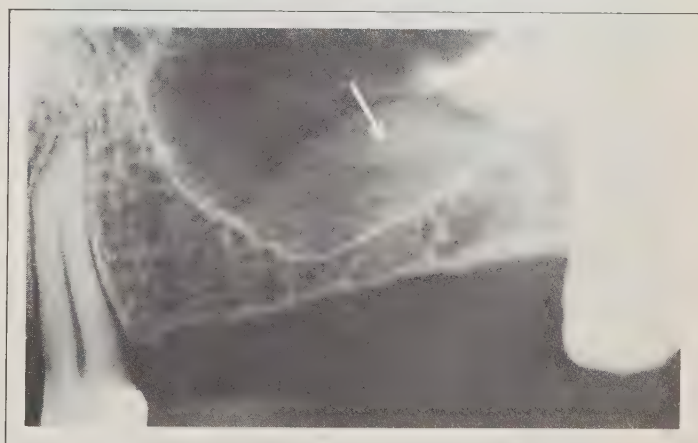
Periapical radiograph depicting maxillary sinus extension into edentulous alveolar bone. The radiopaque shadow in the floor of the sinus is a mucous retention cyst (arrow).
